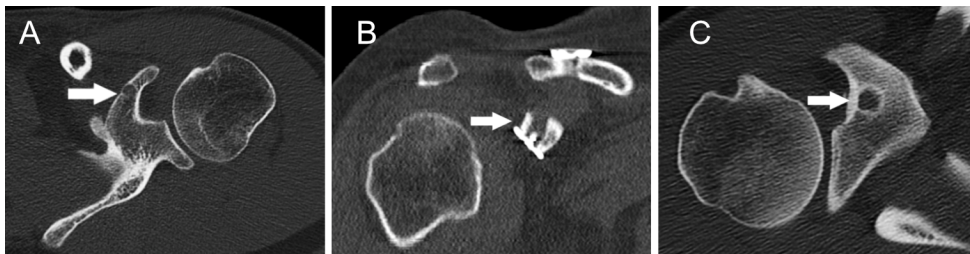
CT scans showing drill tunnels in the coracoid process in three patients.
